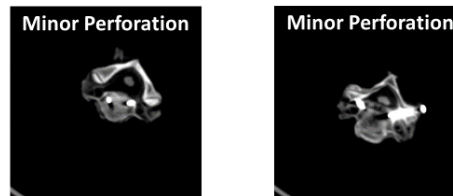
Post-Operation Computed Tomography (CT) Scan for Evaluating the Accuracy of the Subaxial Cervical Pedicle Screw (SCPS) Insertion: Minor Perforation
